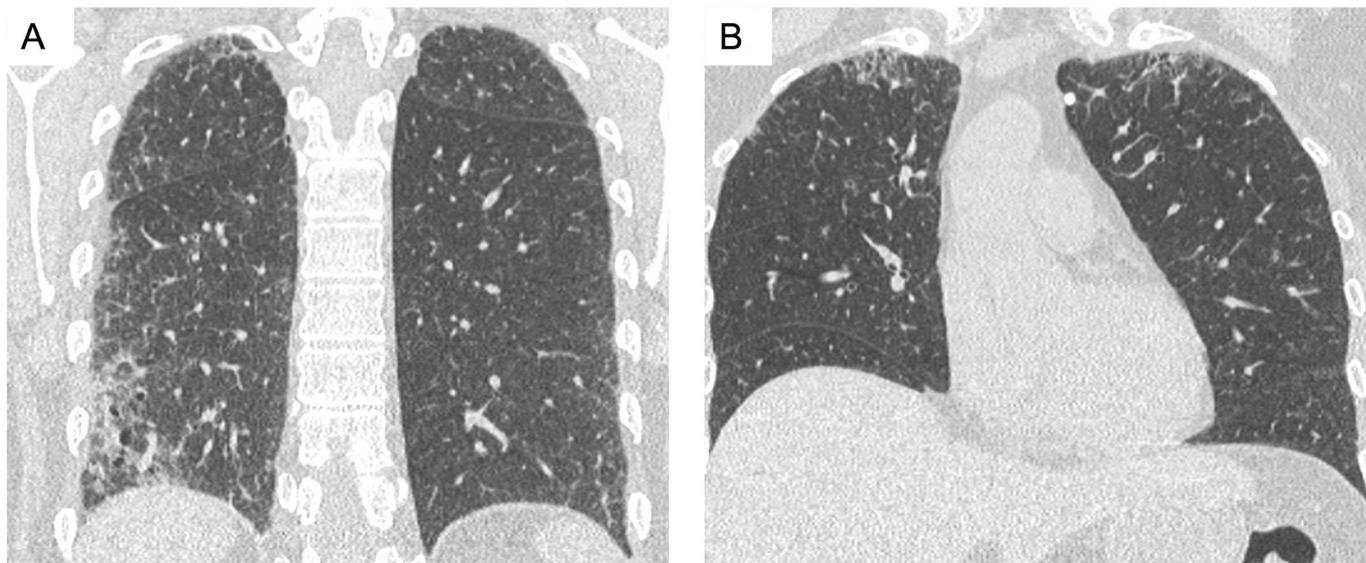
Coronal sections from the high-resolution CT of the chest of our patient demonstrating interstitial fibrosis in the right lower lobe (A) and the lung apices (B).
